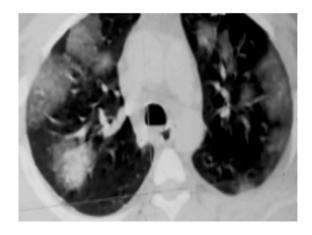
21 female patient complainting of fever and dyspnea, Axial CT chest parenchymal window, Crazy paving appearnce of lungs formed of ground glass attenuation and thickned interlobularsepate.
